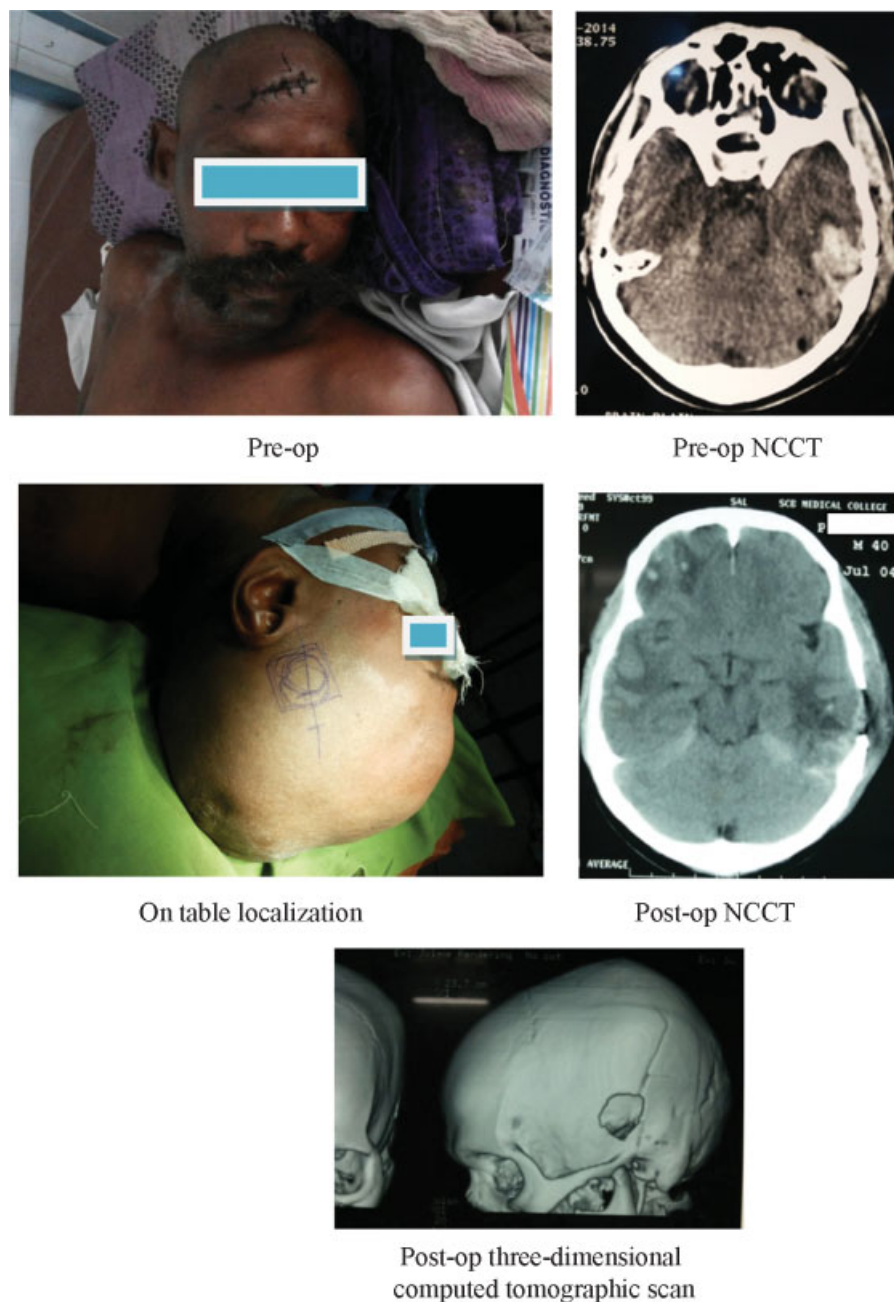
Left temporal contusion. NCCT, noncontrast head computed tomography.
